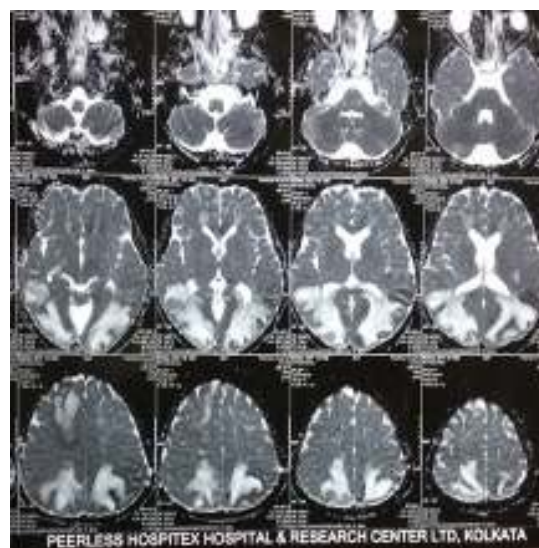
Magnetic resonance imaging of brain showing bilateral parieto-occipital distribution
